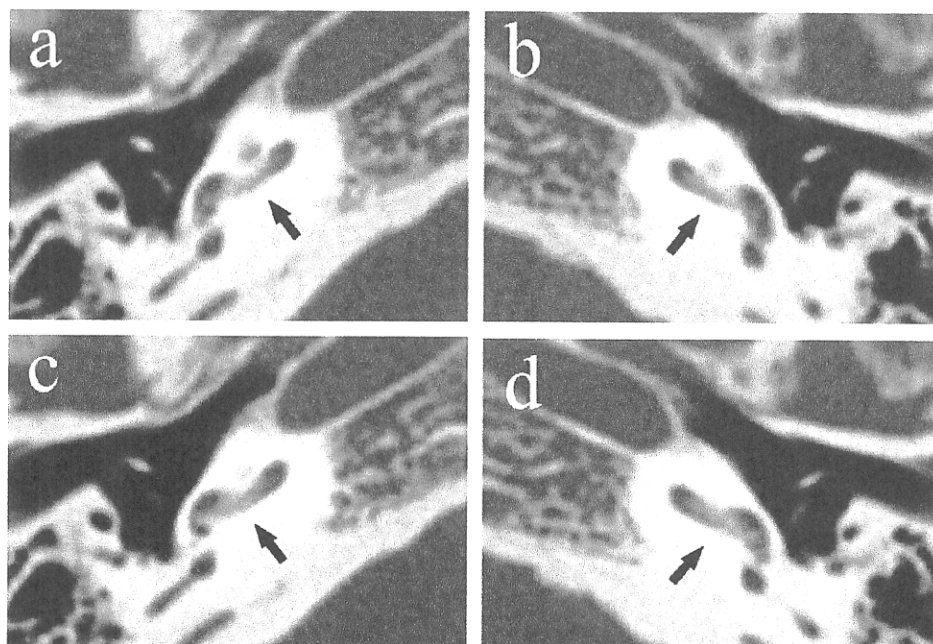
Preoperative high resolution computed tomography revealed progression of ossification of the basal turn in the right (a and c) and left (b and d) ears (arrow). Figure c and d are one slice below than figure a and b.
